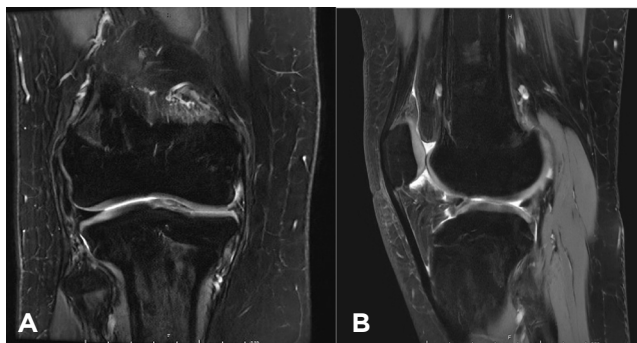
A) T2-weighted Coronal MRI of right knee, demonstrating absence of ACL and PCL; B) T2-weighted Sagittal MRI of right knee, demonstrating absence of ACL and PCL.
